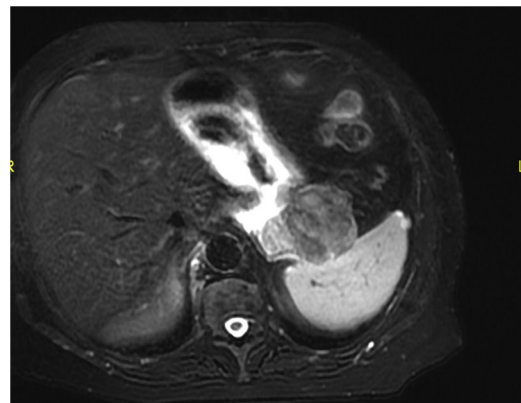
Magnetic resonance imaging showing homogeneous enhancement of the lesion, appearing mainly hypointense both in T1 and T2.
